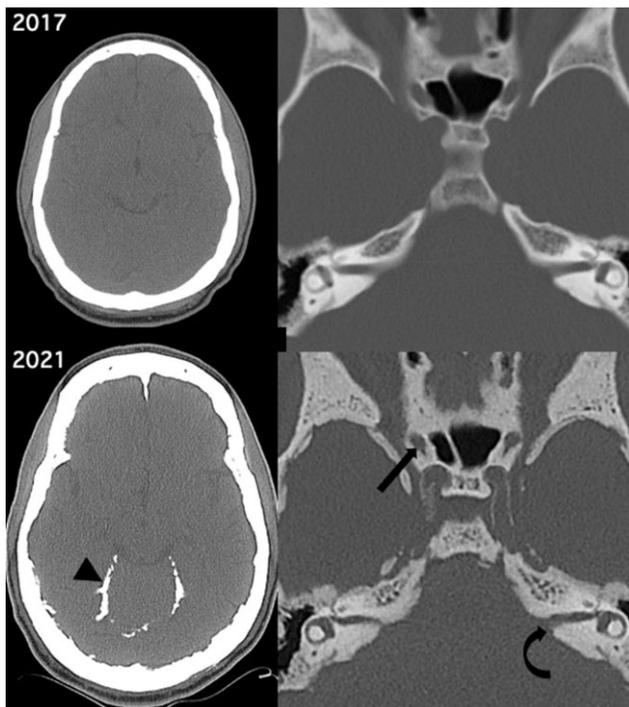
Comparison between CT head from 2017 (top row) and 2021 (bottom row). These show the development of marked intracranial calcifications, most notably involving the tentorial leaflets (arrowhead) as well as the optic canals (straight arrow) and internal auditory canals (curved arrow).
